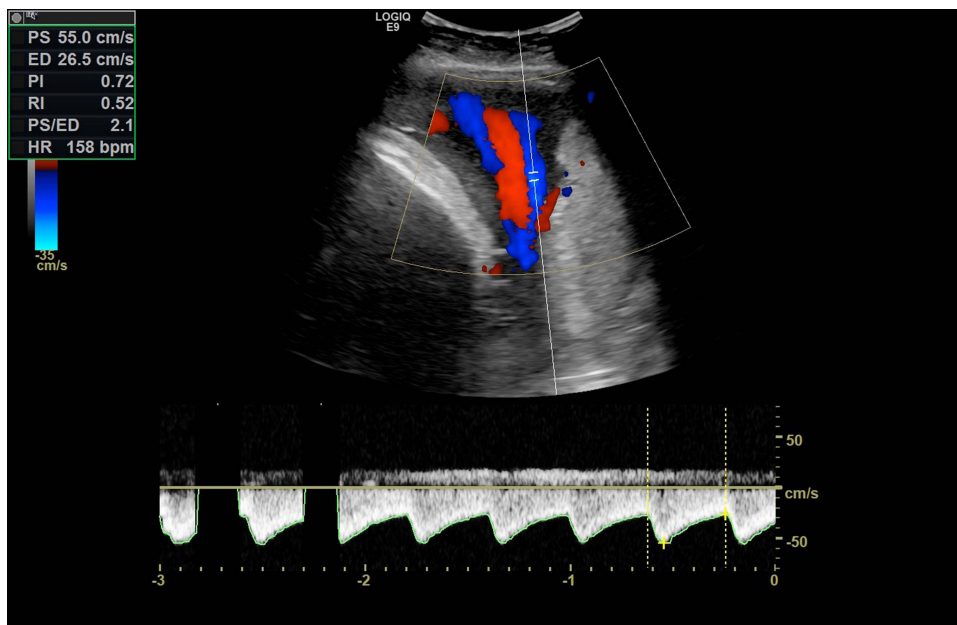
Routine obstetric ultrasound examination 2.
